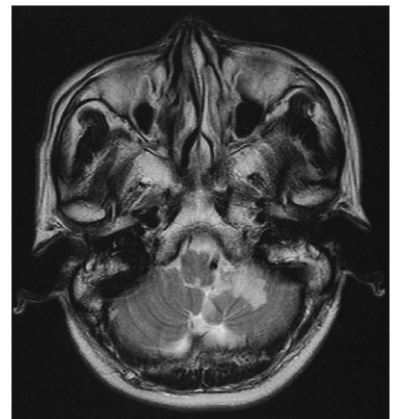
Axial T2-weighted MR image on admission showing high-signal change on the left cerebellum of the posterior inferior cerebellar artery territory.
